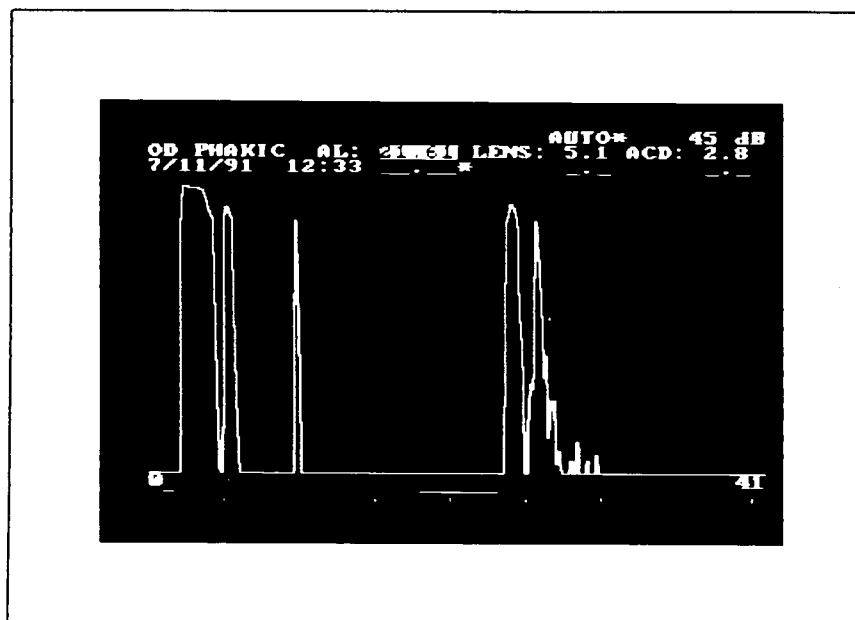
Typical A-scan ultrasound of patient with chronic angle-closure glaucoma, showing high peaks
